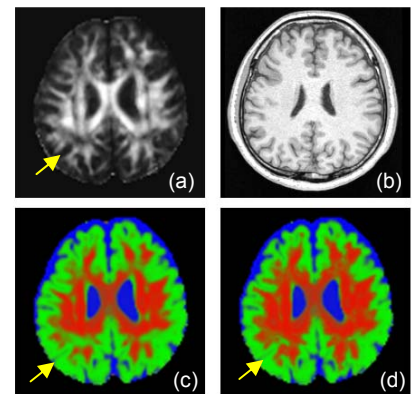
(a) FA map, (b) The structural image (T1-weighted image), (c) result by previous method, and (d) result by proposed method.
